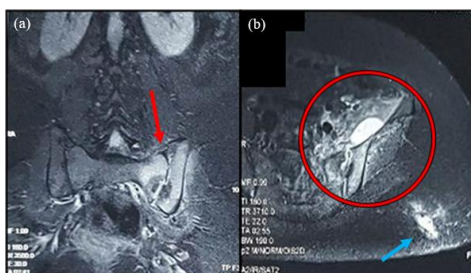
MRI of lumbosacral and pelvis in coronal view (1a) and pelvis in sagittal view (1b) showing the left sacroiliac septic arthritis (red arrow & circle) and left gluteal abscess (blue arrow).
